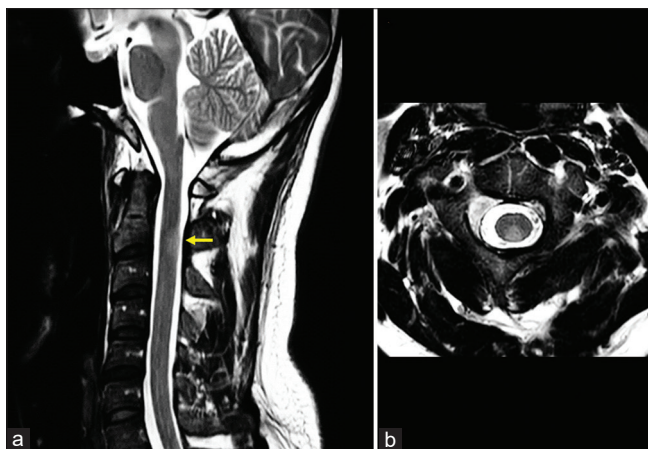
Spinal MRI. (a) Sagittal T2-weighted image shows a short T2 hyperintense lesion at the C2 level (arrow). (b) Axial T2-weighted image shows partial cord involvement, with a triangular lesion involving the dorsal columns
